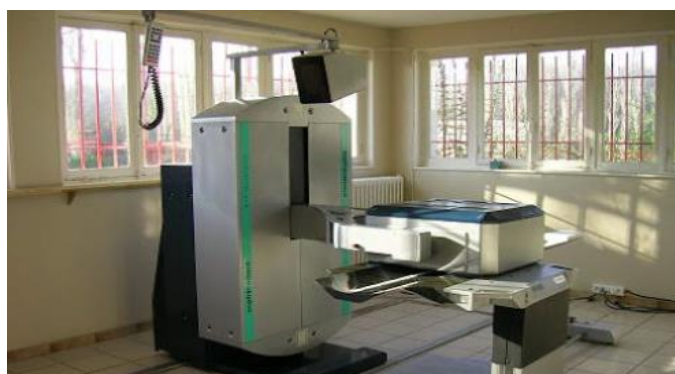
Single-head SOFA gamma camera used at the Department of Nuclear Medicine, University Clinical Center of Kosovo, for planar scintigraphic imaging and routine radionuclide diagnostic procedures.
